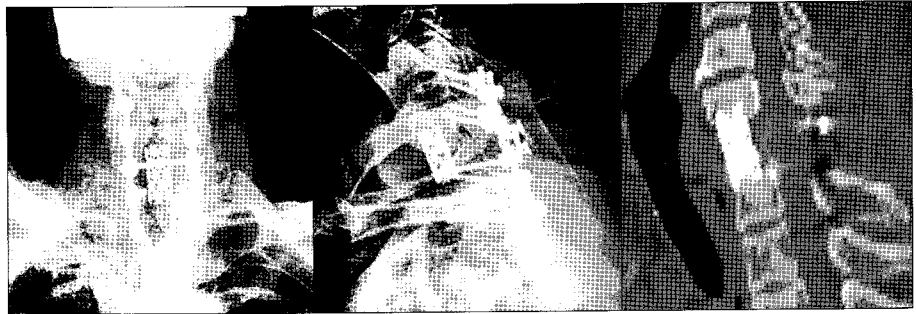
Postoperative plain radiograph and computed tomography reconstruction of the cervical spine with physiological realignment and anterior and posterior fusion.
